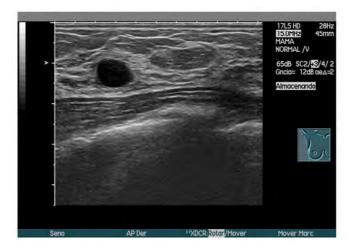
Sample breast ultrasound scan [19].
